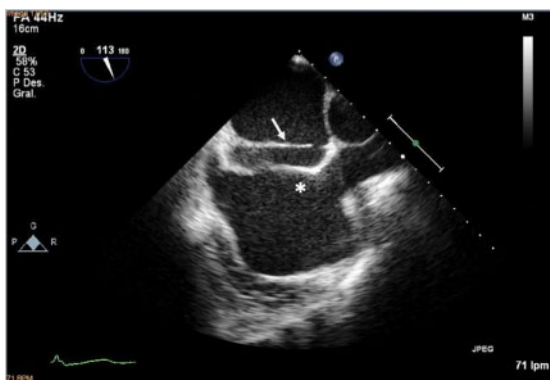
Transoesophageal echocardiogram double atrial septum and interatrial communication: Arrow: septum and ostium primum. Asterisk: accessory atrial septum and its ostium.
